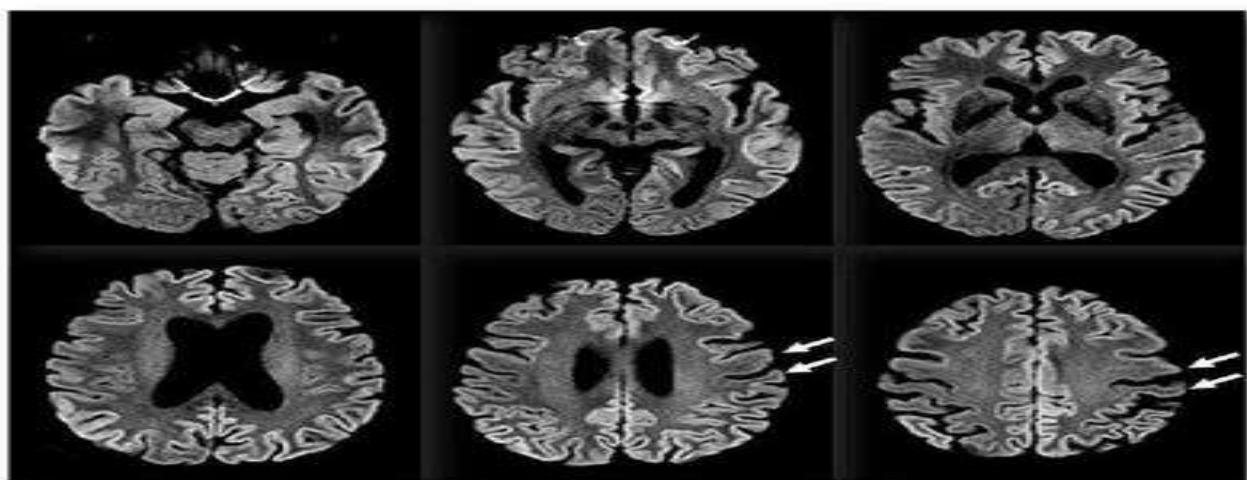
Magnetic Resonance imaging in the diagnosis of Creutzfeldt-Jakob disease.
